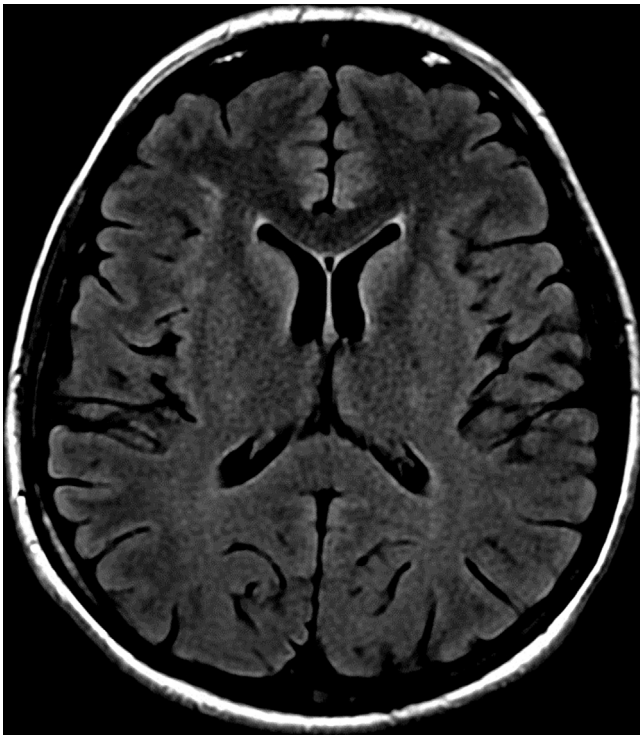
An MRI brain scan (FLAIR sequence) showing nonspecific sites of hyperintense tissue signal indicative of mild perivascular gliosis.
